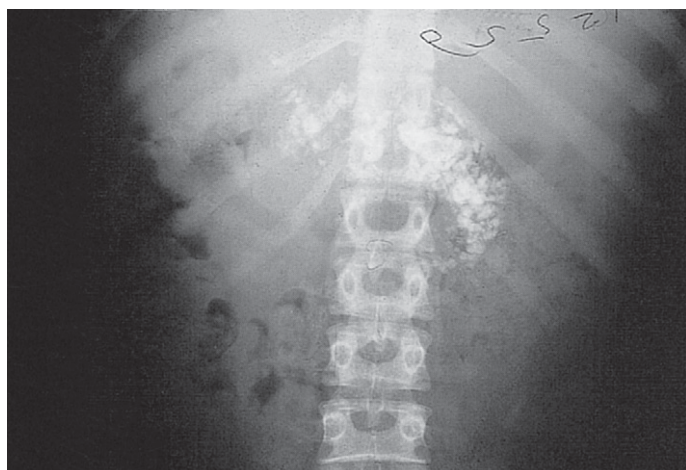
Abdominal radiograph showing calcified pancreas in the chronic calcific pancreatitis syndrome. There was no history of alcohol excess or infant malnutrition; aetiology was therefore undetermined.
